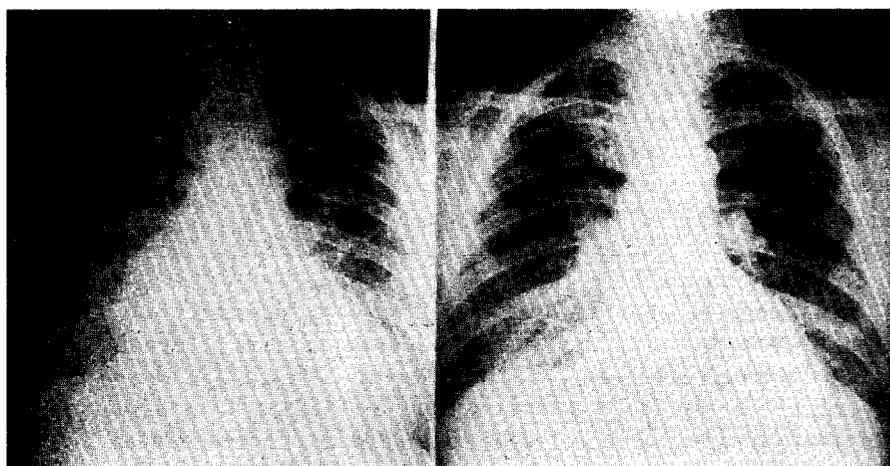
The reduction in cardiac size and clearing of pulmonary congestive changes in Patient R. Mc. (Case 4). The roentgenogram on the left was taken prior to treatment and that on the right was taken after seven months of continuous treatment with veratrum viride.
